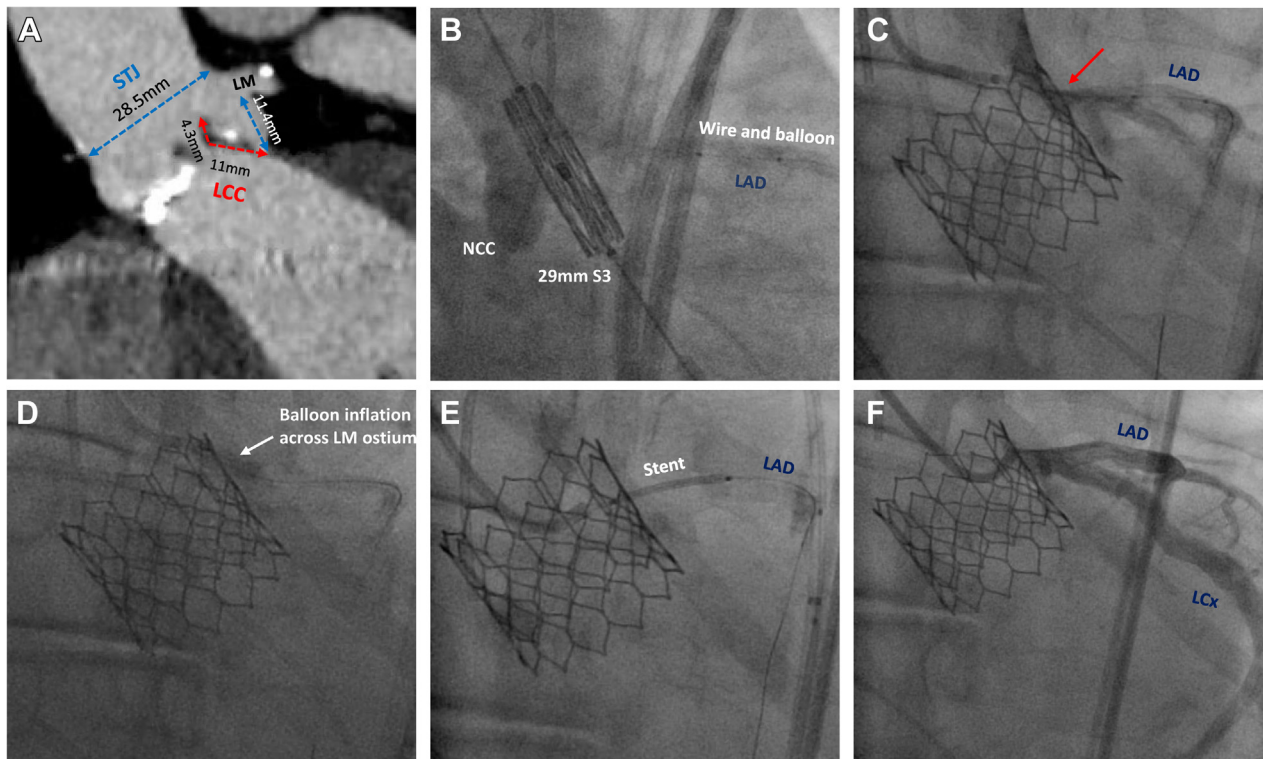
Case of threatened left main (LM) obstruction after valve deployment treated successfully with stent placement. (A) Pre-transcatheter aortic valve replacement (TAVR) computed tomography (CT) showing left coronary cusp (LCC) length greater than LM ostial height and a relatively small sinotubular junction (STJ). (B) LM protection with coronary wire and unexpanded balloon in the left anterior descending (LAD). (C) Angiogram after valve deployment with impaired flow in the left system caused by the displaced LCC (red arrow). The S3 valve occupies the entire STJ. (D) Balloon inflation in the area between the valve stent and LM ostium. (E) A drug-eluting stent was deployed coaxially in the LM through the S3 valve frame. (F) Final angiography after LM stenting with Thrombolysis in Myocardial Infarction (TIMI) 3 flow in the left system.
